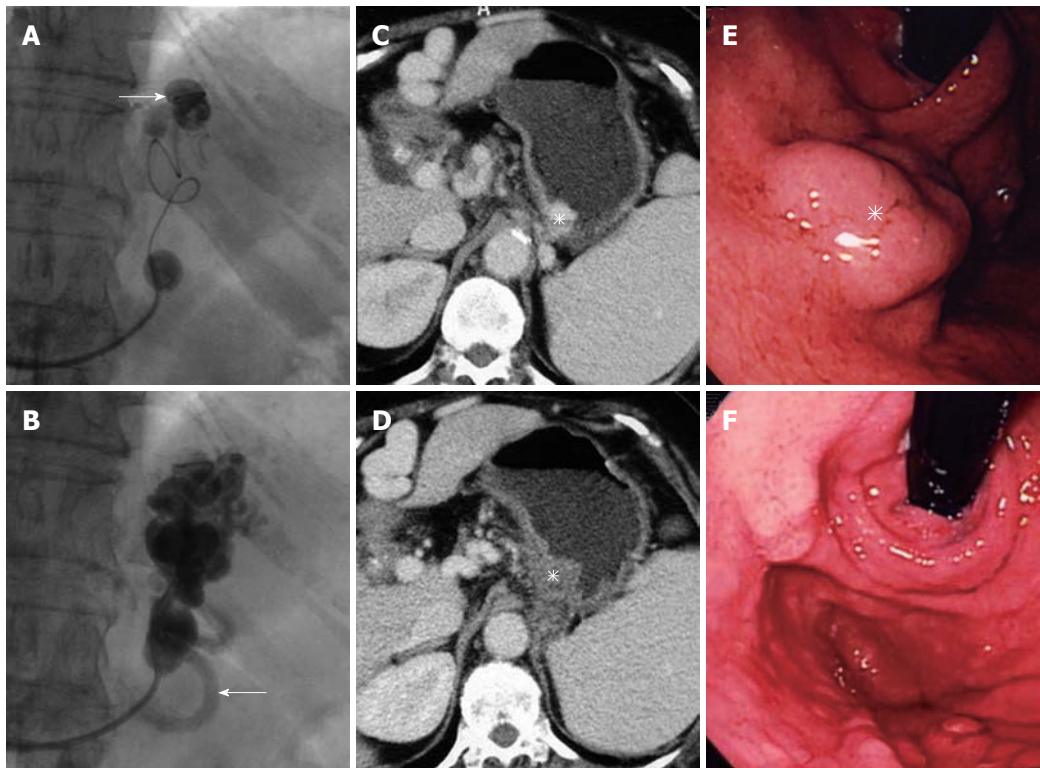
Selective injection of the sclerosant. A: A microcatheter is navigated close to the gastric varices, and the sclerosant is selectively injected through the microcatheter (arrow); B: The gastric varices and gastrorenal shunt are fully filled with the sclerosant with contrast medium, and the afferent vein (arrow) is opacified; C: Contrast-enhanced computed tomography (CE-CT) before balloon-occluded retrograde transvenous obliteration (BRTO) shows gastric varices (asterisk); D: CE-CT one week after BRTO shows complete thrombosis of the varices (asterisk); E: Endoscopy before BRTO shows tumor-like varices (asterisk) in the fornix of the stomach; F: Endoscopy 3 mo after BRTO shows complete disappearance of the varices.
